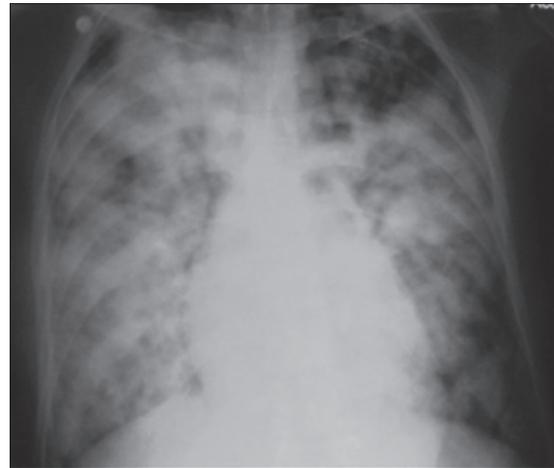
Chest X-ray showing bilateral haziness all over the lung fields
